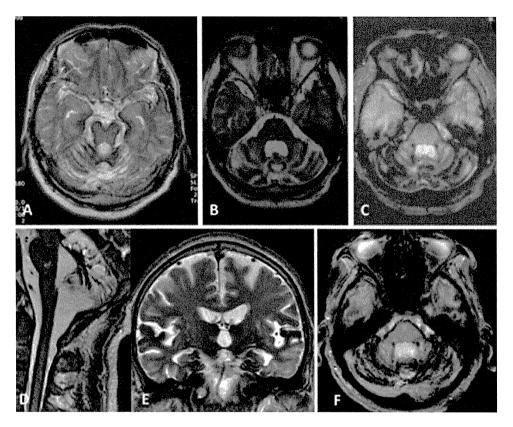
Brain MRI images of the patient described in this report. (A) T2-weighted image (T2WI; 1.5 T) at age 54. (B–F) T2WI (B, D, E) and T2*-weighted images (T2*WI) (C, F) obtained with a 3-T MRI scanner at ages 58 (B, C), 63 (D), 64 (E), and 66 (F). T2WI and T2*WI show hypointense rims surrounding the brainstem, cerebellum, and temporal lobes as well as the spinal cord. Severe atrophy of the cerebellum is also evident. Mild progressive atrophy of the cerebellum may have occurred over the course of the12-year period.
